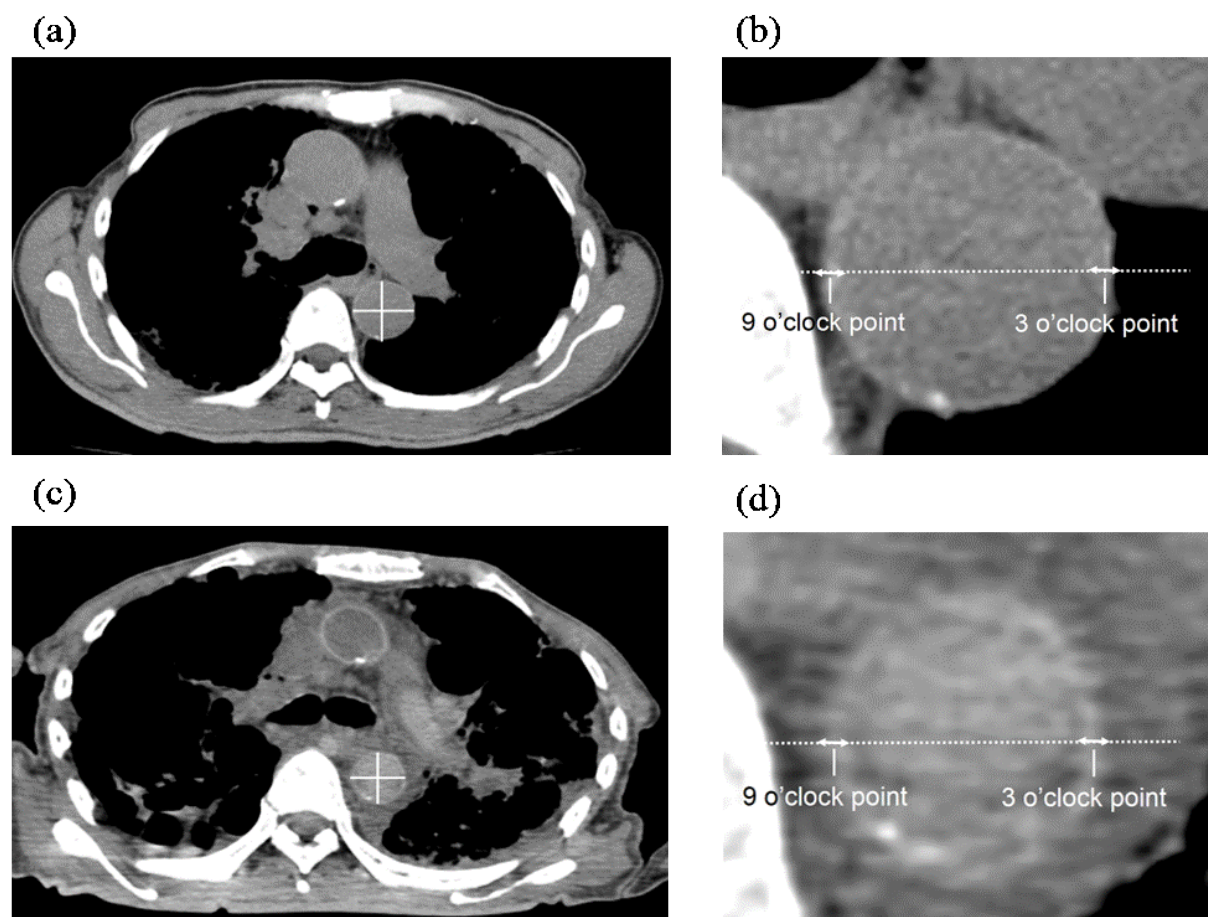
Antemortem and postmortem CT images of a 75-year-old man.
